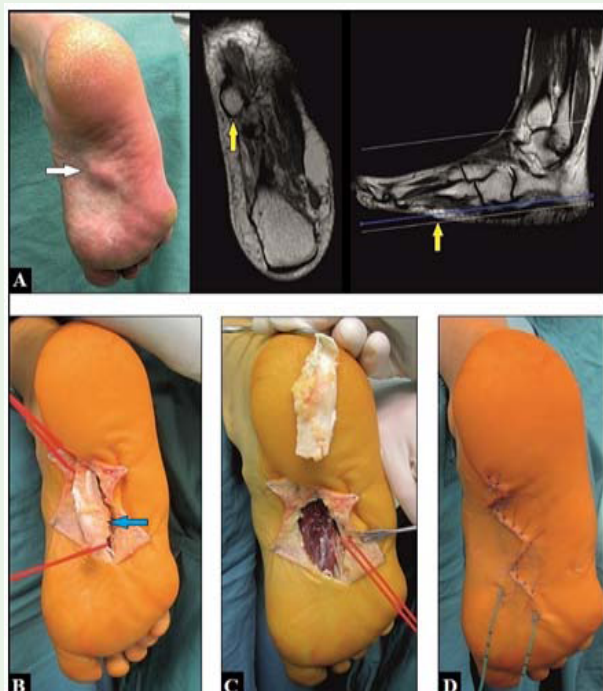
(54-year-old female, plantar fibromatosis, right foot): (A) Preoperative clinical findings and magnetic resonance imaging, the nodule is partially adherent to the skin (arrows). (B) Intraoperative, after careful dissection of the nodule (arrow) from the skin. (C) Intraoperative, after total fasciectomy. (D) Intraoperative, primary closure of wound, the further course was uneventful.
